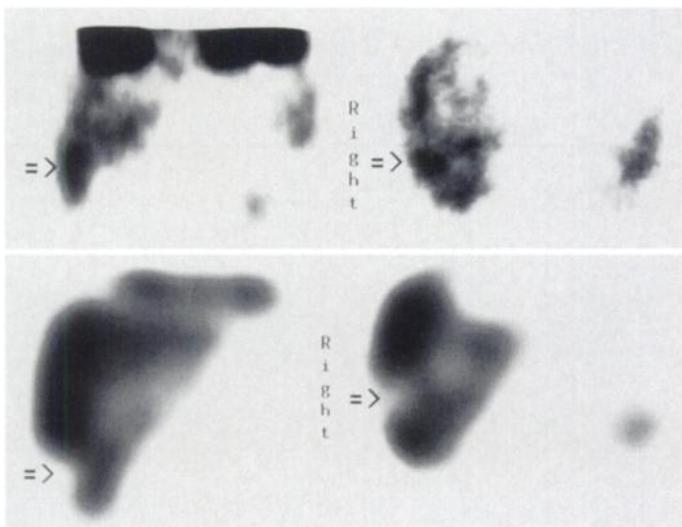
Liver metastases (arrow) visualized by ^{123}I -VIP and ^{111}In -CYT-103 (Table 5, Patient 1). Corresponding SPECT-reconstruction indicated the liver metastases in a patient suffering from colonic adenocarcinoma. Upper panel: ^{123}I -VIP SPECT study performed at 2 hr after injection (left: coronal slice, right: transverse slice). Lower panel: ^{111}In -CYT-103 SPECT study performed at 48 hr after injection (left: coronal slice, right: transverse slice).
